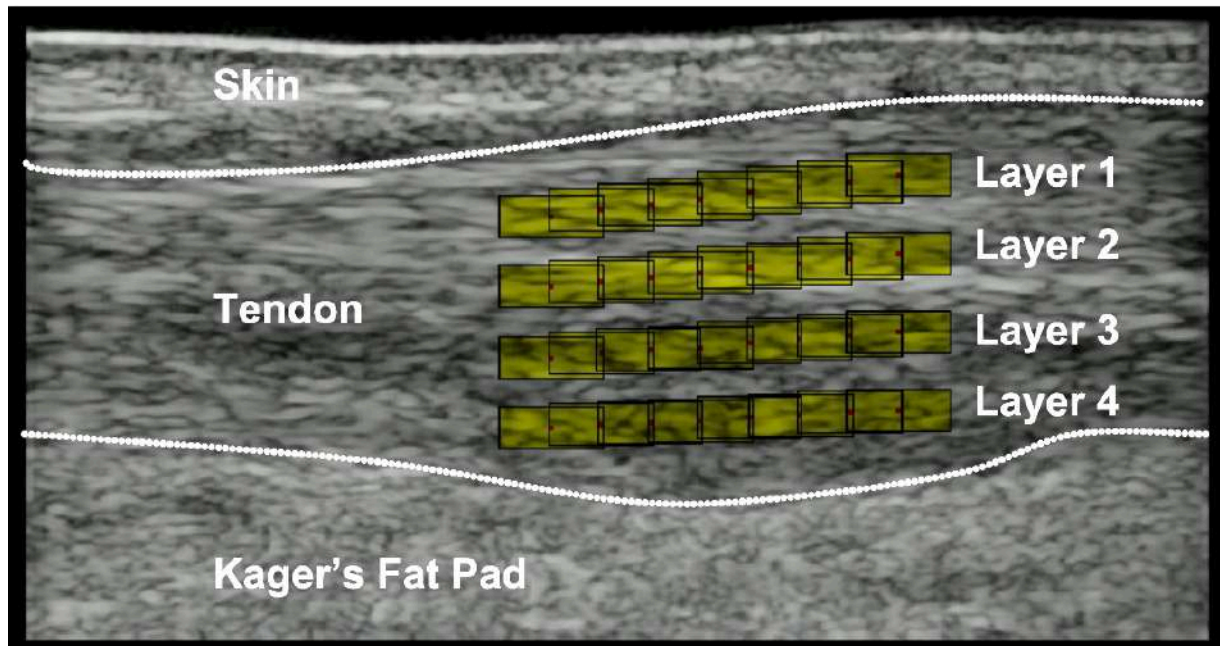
Example of an ultrasound image where individual kernels were identified and tracked within the Achilles tendon. The layer 1 is the most superficial, the layer 4 is the deepest. It is not possible to know, from such image, which layer belongs to which subtendon. From Coupe et al. (2020).
